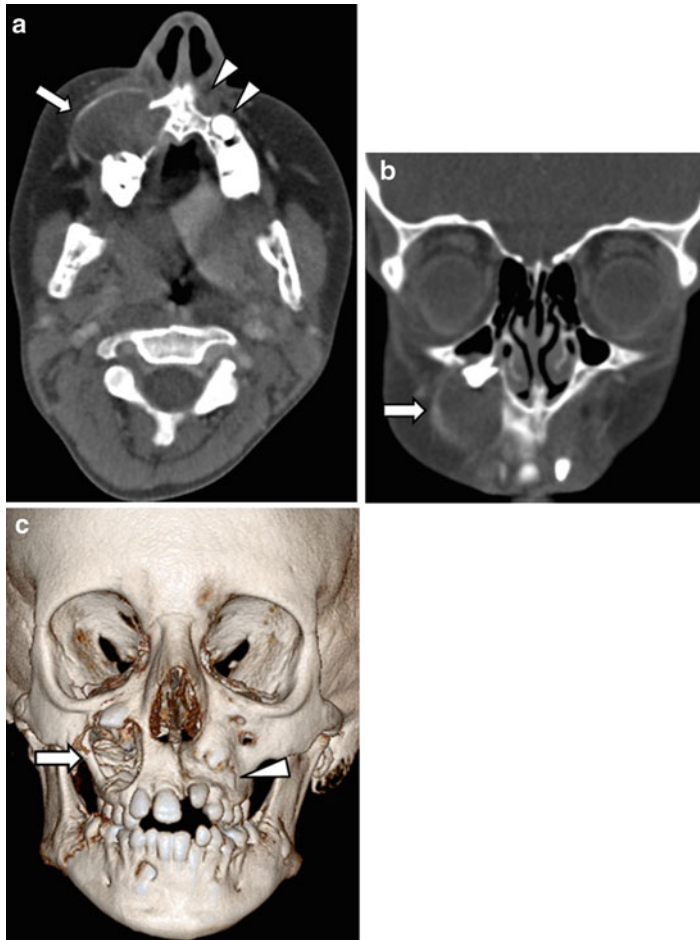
(a–c) An 8-year-old female with a history of macrocephaly, developmental delay, pyloric stenosis, and multiple odontogenic keratocysts. A *PTCH1* p.Leu106Arg mutation confirmed the diagnosis of Gorlin syndrome. The mother was affected with Gorlin syndrome and had a history of skin cancer removal. CT images (a–c) demonstrate an expansile 3.5 cm fluid attenuating lesion in the right maxilla (arrows) causing destruction of the inferior wall of the maxillary sinus with extension into the right
